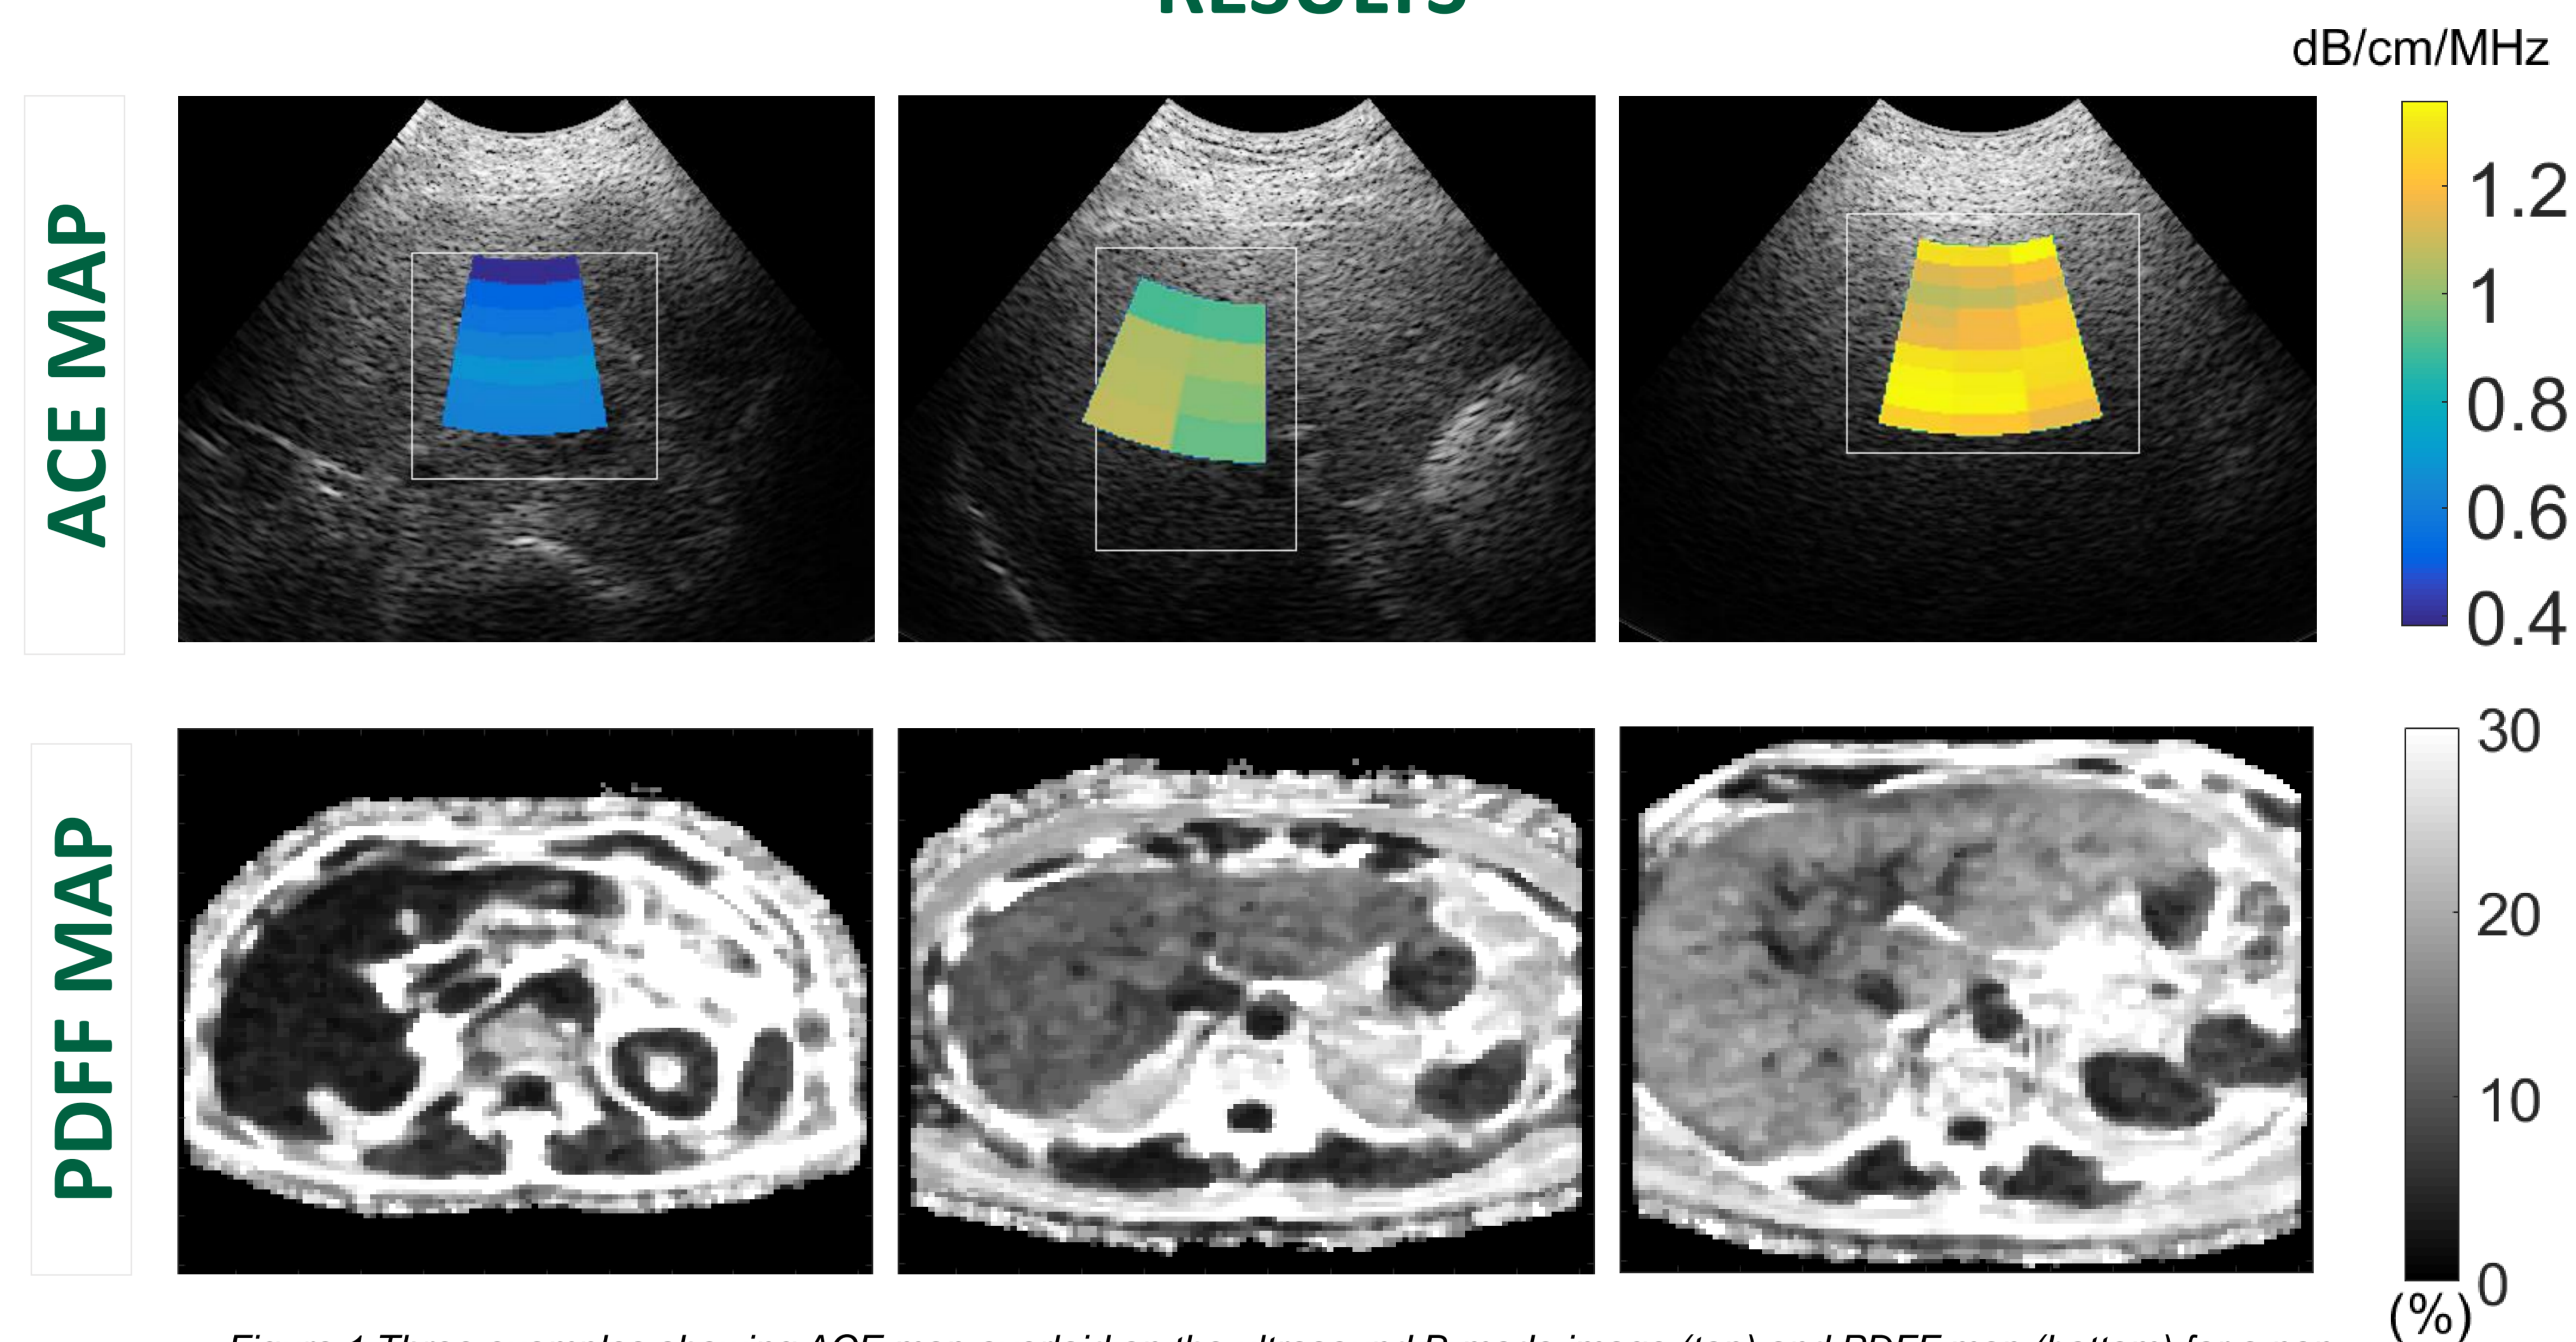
Three examples showing ACE map overlaid on the ultrasound B-mode image (top) and PDFF map (bottom) for a non-steatosis (left), a mild steatosis (middle) and a severe steatosis (right) case.
